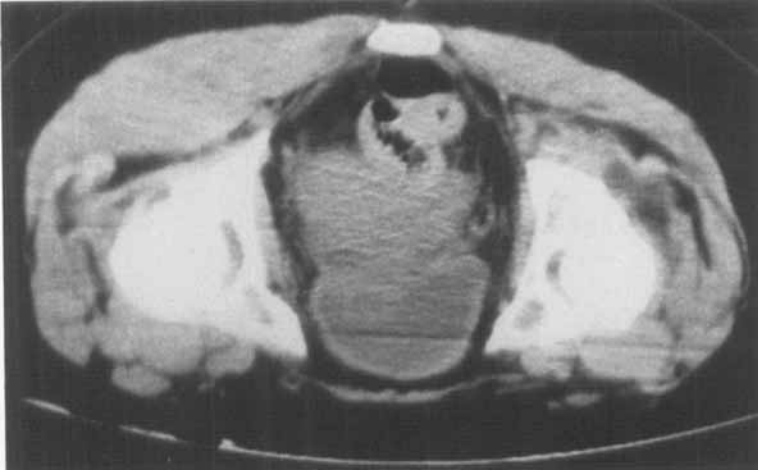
CT scan of the hip joints. There is marked atrophy of the right gluteal muscles and a radiolucency in the region of the right gluteus minimus muscle.
